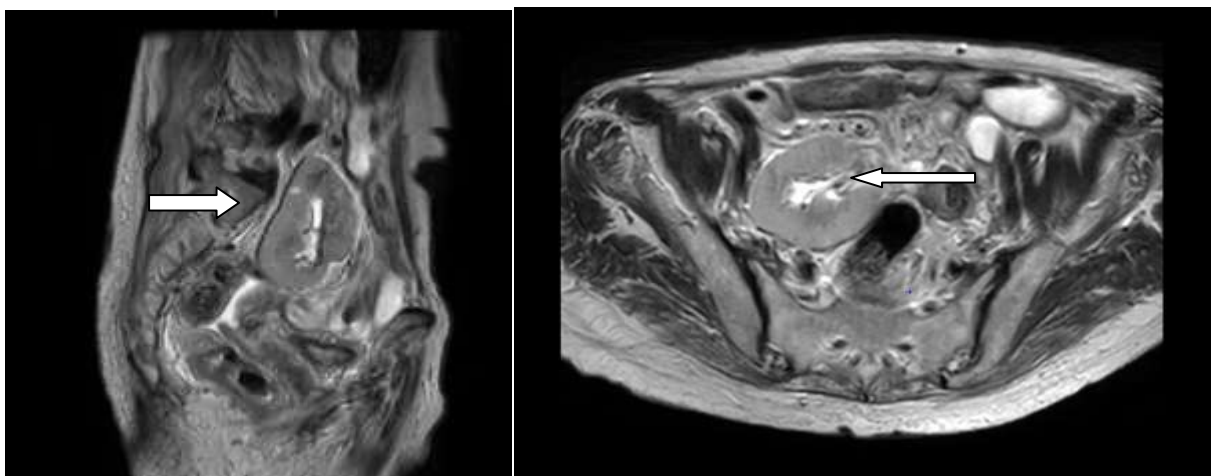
Magnetic Resonance Imaging images (Sagittal and axial) in T2 sequence showing the pelvic kidney
